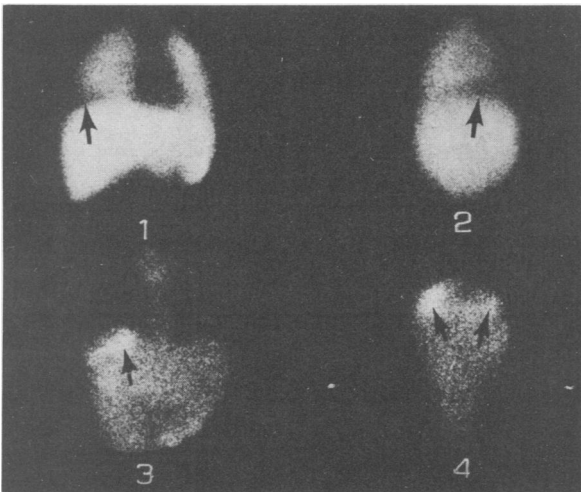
(Case 3) Anterior (1) and right lateral (2) liver-lung scintigraphs using ^{99m}Tc -sulfur colloid and ^{99m}Tc -human albumin microspheres are equivocal for evidence of a subphrenic abscess while similar views in the same positions (3,4) using ^{67}Ga citrate clearly show ^{67}Ga localization in the right subphrenic space. Note that the loculated posterior abscess seen with ^{67}Ga citrate (4) is not evident on the ^{99m}Tc study (2).
